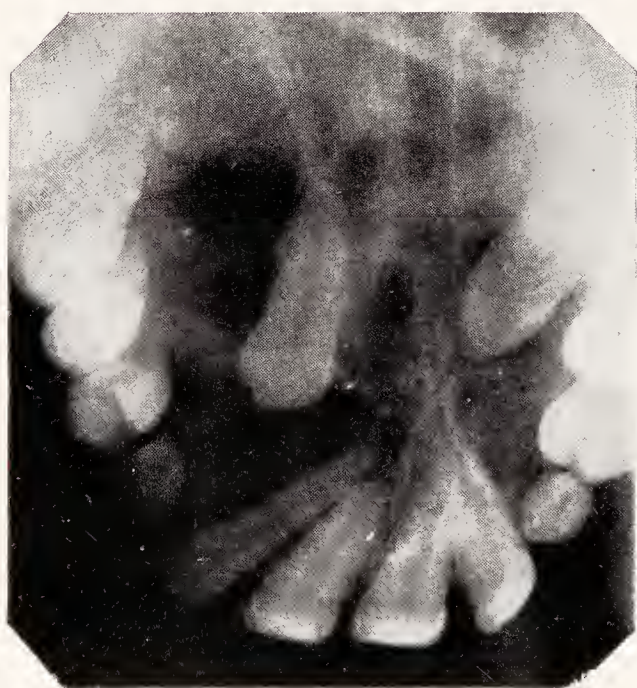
Radiograph of a large dentigerous cyst that developed around the crown of an embedded upper left cuspid. (Ennis.)
